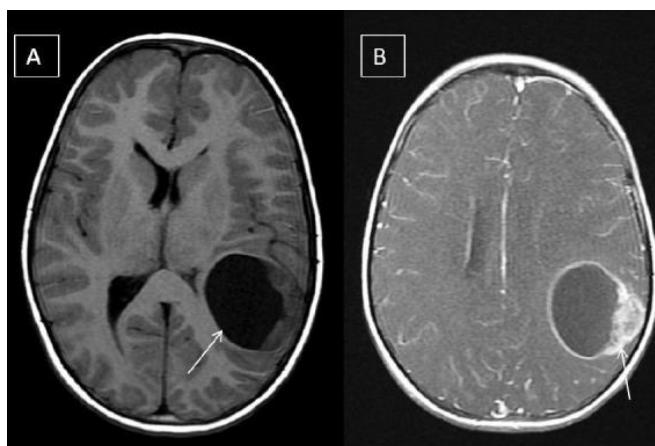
Axial T1W (A) and contrast-enhanced T1W (B) MRI images in a 9-year-old boy who was treated for ALL 4 years back and now presented with seizures, reveal a predominantly cystic space-occupying lesion with an enhancing solid component along its lateral wall (arrow). The imaging features are suggestive of a low-grade brain tumor; however turned out to be a primitive neuroectodermal tumor [39].
